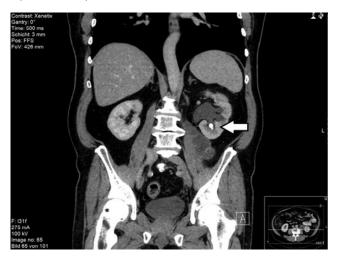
CT scan showing lower pole stone of left kidney (shown with *arrow*).
